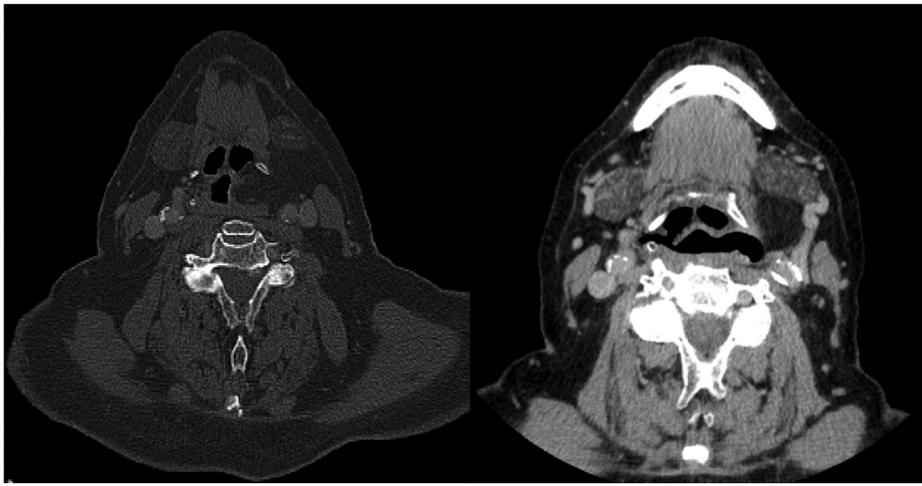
Left: preoperative CT showing a bulging partially obstructive mass. Right: revealed the reduced volume of the mass.
